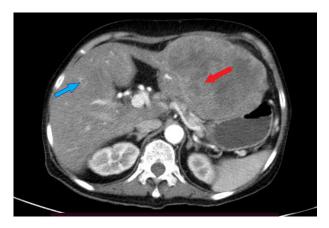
CT image of the mass lesion arising from duodenum (red arrow) with liver metastases (blue arrow)
